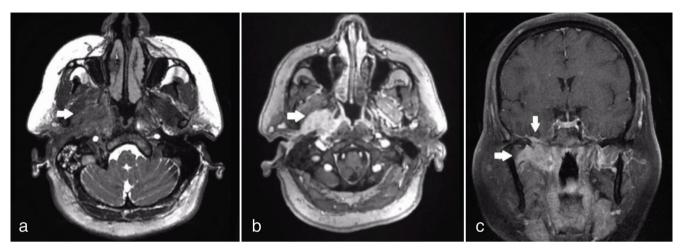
Magnetic resonance imaging examination revealed a 39x28 mm lesion, in the right parapharyngeal and masticator area, extending posterolaterally to the carotid sheath and posteriorly to the retropharyngeal area. The lesion appeared hypointense on T2-weighted images (Figure 2a) and exhibited dense heterogeneous contrast enhancement on post-contrast series (Figure 2b). The lesion involved the right pterygoid and masseter muscles, with intracranial extension via the right infratemporal fossa. Coronal T1-weighted contrast-enhanced imaging demonstrated skull base invasion through the foramen ovale, resulting in 6.5 mm dural thickening in the posteroinferior aspect of the temporal lobe (Figure 2c). Additionally, the lesion in the right tympanic cavity and external auditory canal (EAC) extended to the nasopharynx via the Eustachian tube, with intense T2 signal increases observed in these areas. Endoscopic nasopharyngeal examination revealed slight fullness in the right rosenmüller fossa. Otoscopic examination demonstrated diffuse maceration and bony erosion in the right EAC, as well as a thickened tympanic membrane. Punch biopsies were obtained from both the nasopharynx and the right EAC.
